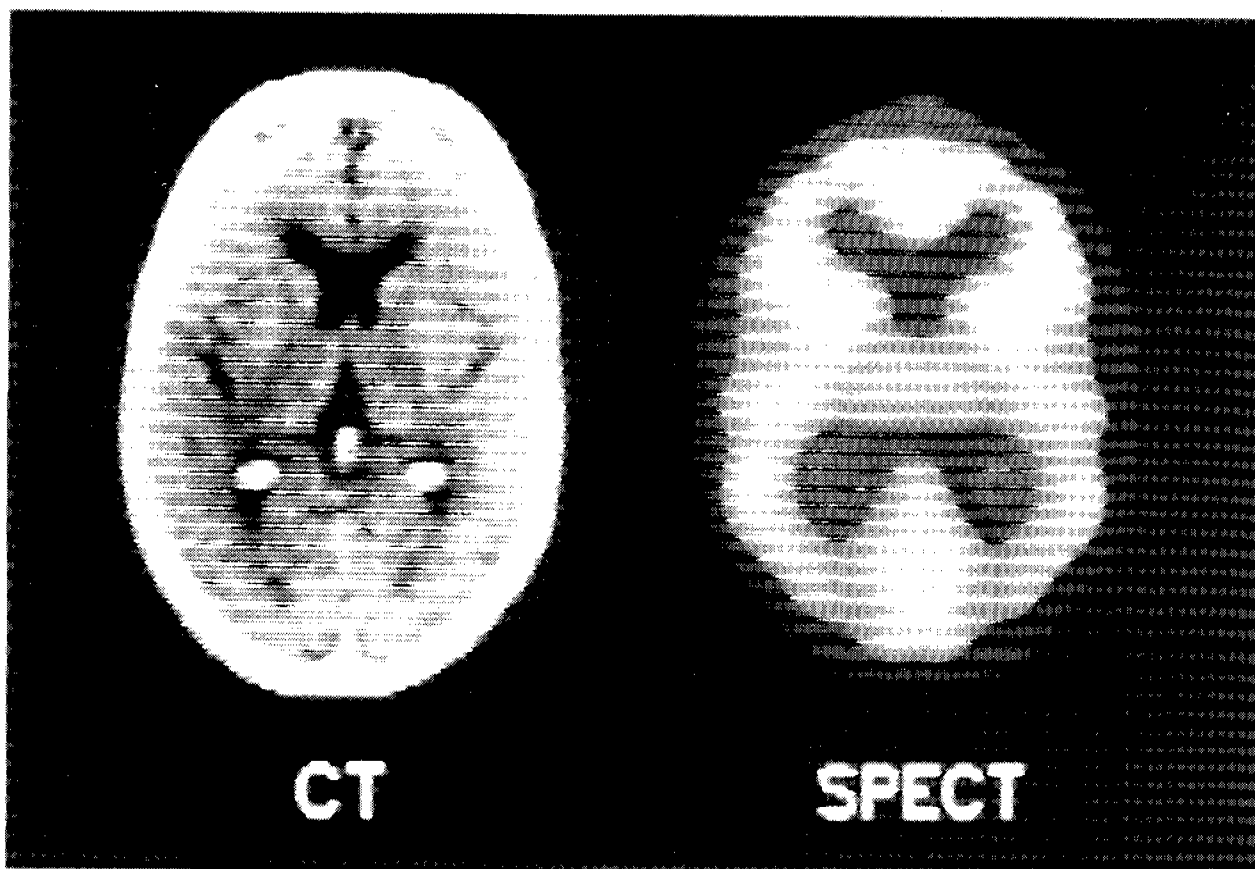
A normal *computed tomography* (CT) study (left) and a normal *single-photon emission computed tomography* (SPECT) study following the administration of the radiopharmaceutical technetium-99m exametazime (right). [courtesy of Dr. R.A. O'Connell (1)]
